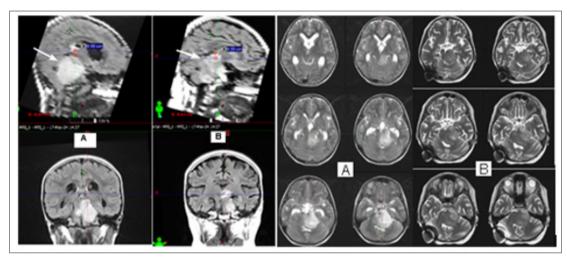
Comparison of MRI A/ before and B/ after combined with Temidal radiotherapy - MRI data on leptomeningeal pseudoprogression of the tumor on the left up to the ventricles by 0.5 cm.
